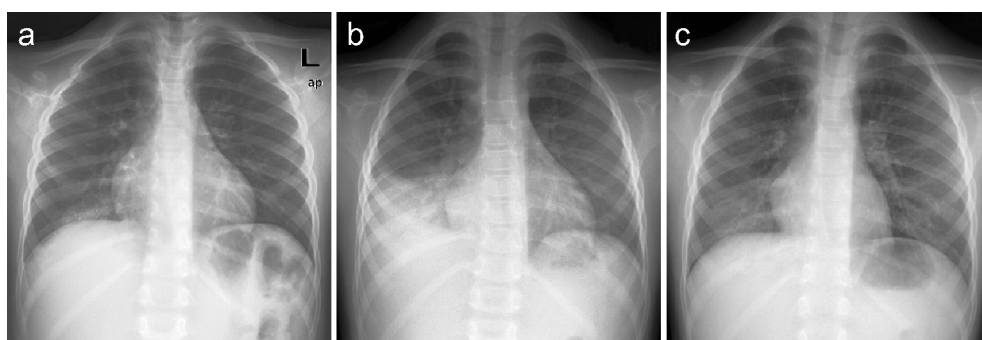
Development of pneumonic infiltrates in a five-year old boy with pneumonia. Chest radiograph on admission (a), one day after admission (b), and five days after admission (c).
